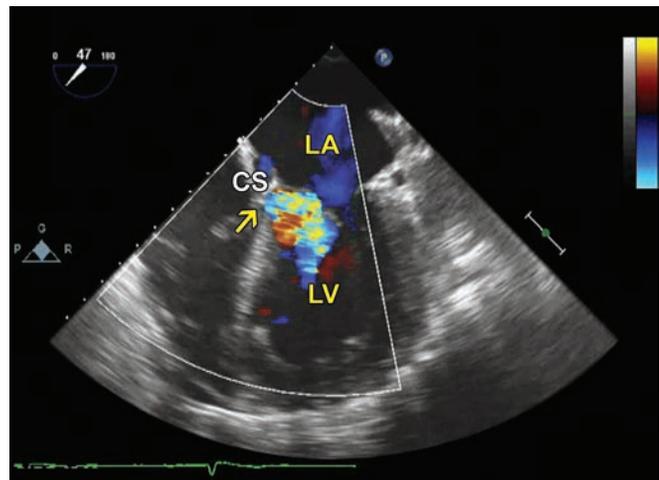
Transesophageal four-chamber view demonstrating a fistulous connection (arrow) between the coronary sinus and left atrium. (CS: Coronary sinus; LA: Left atrium; LV: Left ventricle).
